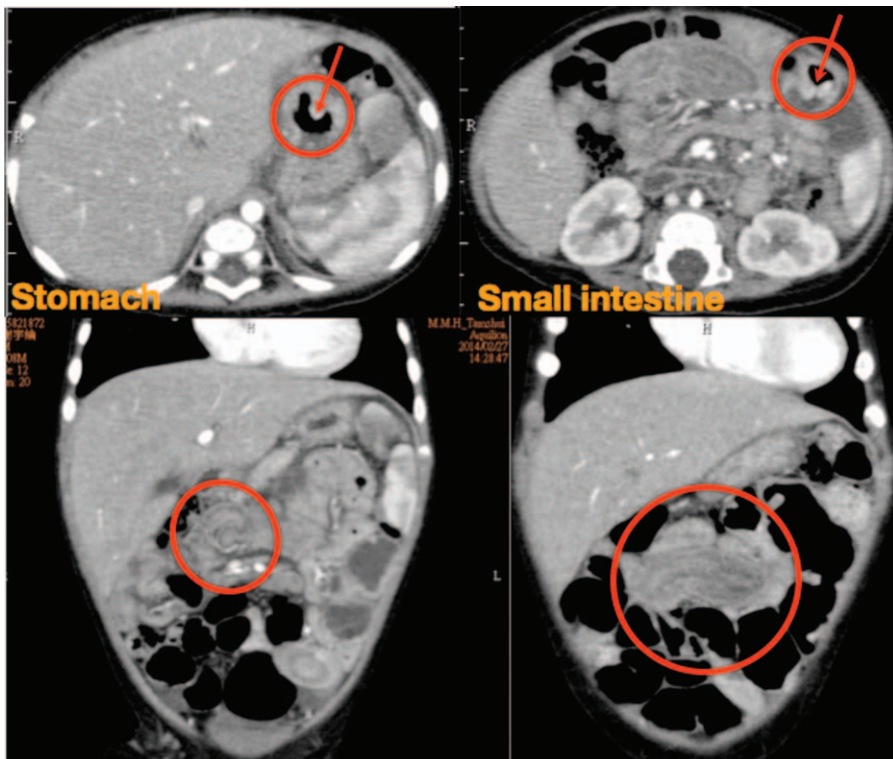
Abdominal computed tomography showed multiple nodules within the stomach, small intestine (including duodenum, jejunum, and ileum), and descending colon leading to intussusception.
